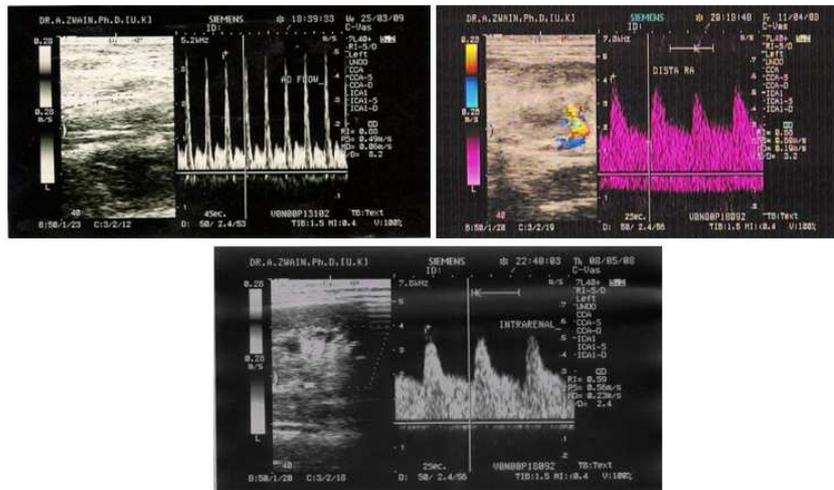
A Doppler spectral wave form in a healthy rabbit, showing (A): aortic blood flow, (B): renal and (C): intra-renal artery blood flow velocities: PSV, EDV (m/s), RI and S/D ratio.
